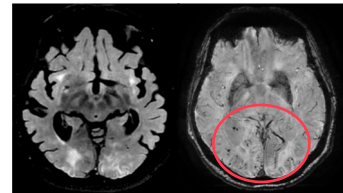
Axial FLAIR and SWAN during CAAri
